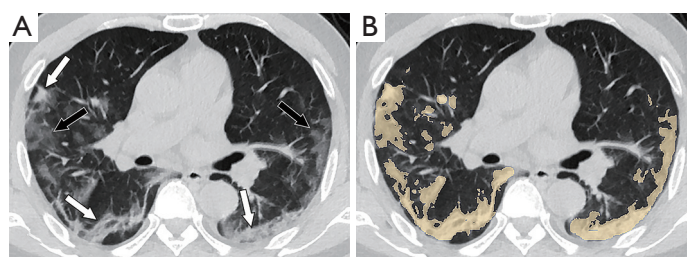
Thin-slice CT scan of a 57-year-old man with COVID-19 without dyspnea after discharge (obtained 9 days after onset) showing patchy consolidations (white arrows) and GGOs (black arrows) mainly in the bilateral subpleural region (A). 3D slicing was used to segment all lesions (B). CT, computed tomography; COVID-19, coronavirus disease 2019; GGOs, ground-glass opacities.
